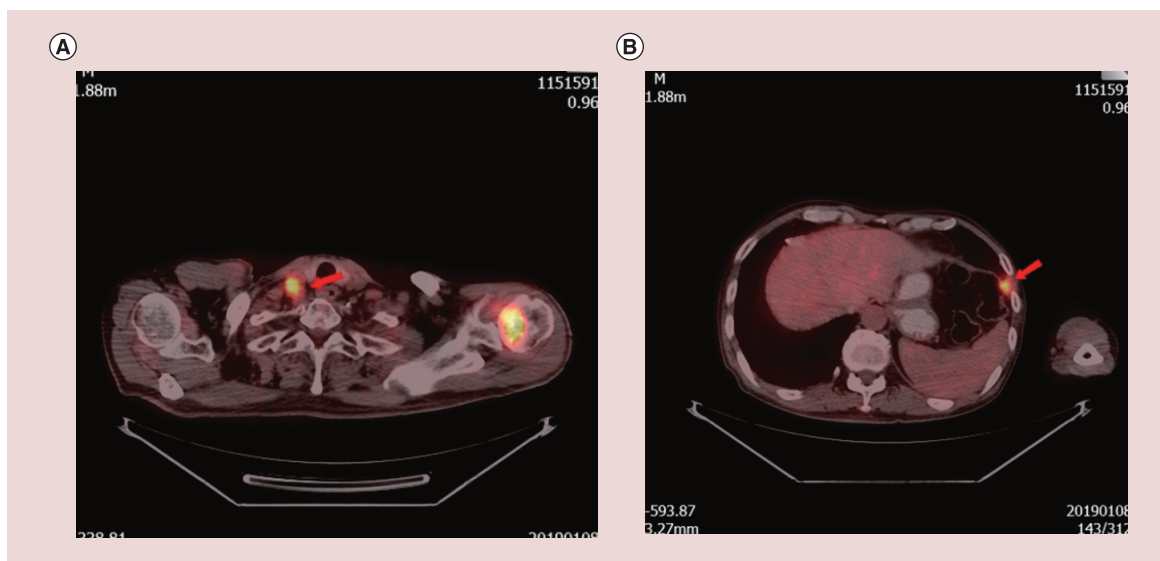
Representative images of positron emission tomography-CT scan showing a strong cancer-related uptake of fluorodeoxyglucose. (A) The radioactive uptake by the right clavicle lymph node increased and dissolved the destruction of the left humeral head. (B) Increase of the radioactive uptake by pleural nodules in the left anterior inferior wall.
